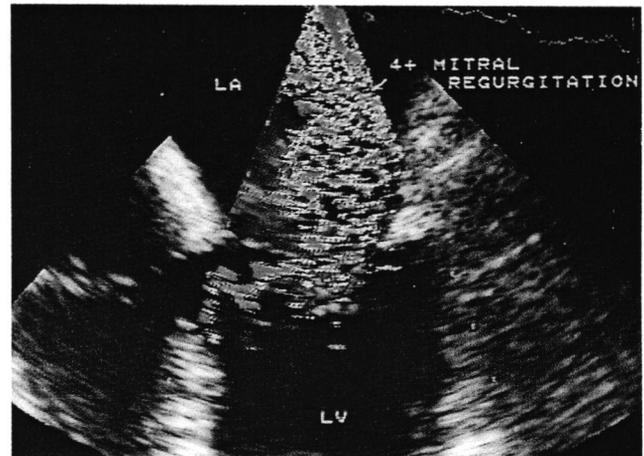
Color flow Doppler of Figure 6 demonstrating 4+ mitral regurgitation.
